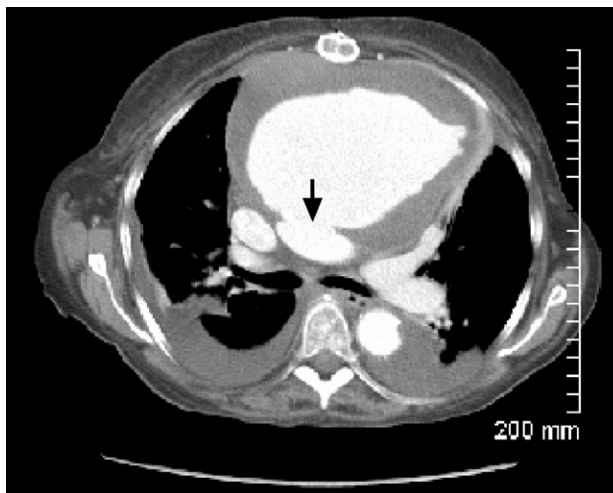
Computed tomogram of the chest (cross-sectional view) shows a large, narrow-necked pseudoaneurysm (arrow) arising from the ascending aorta and lined circumferentially by intramural thrombus.
